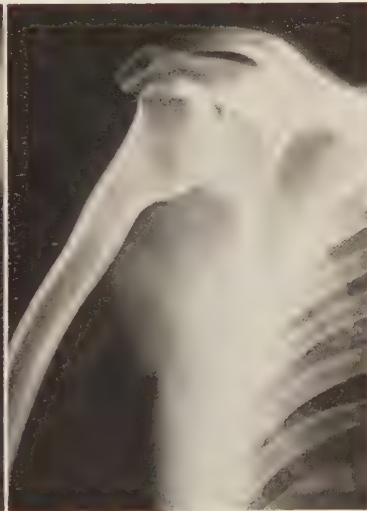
Radiograph of the right scapular region of individual IV-B.
